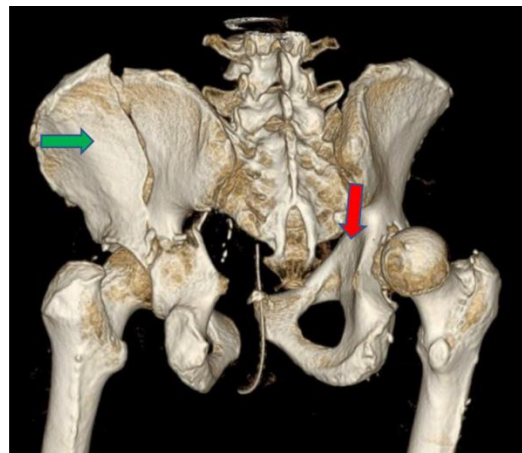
Figure III (Case one): 3-D CT pelvic re-construction posterior view showing the pubic symphysis disruption >2.5cm and complete fracture through the left ischium and iliac crest (green arrow). The posterior dislocation of the right hip with a fractured posterior acetabular wall can also be seen (red arrow).
